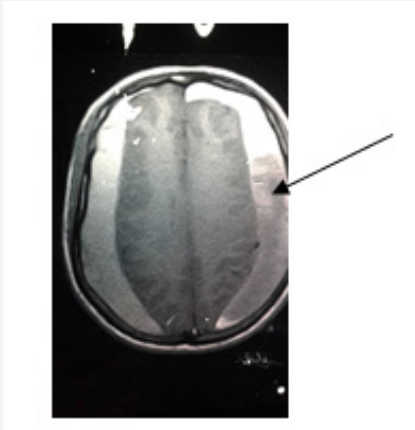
Axial brain computed tomogram at the level of the lateral ventricles in a 55 year old patient. Bilateral crescentic isodense extra-axial bleeds outling the inner table of the skull with right more than left (black arrows) are shown. This lesion extend from the frontal region to the parietal region. Note mild subfalcine ventricular herniation to the left.
